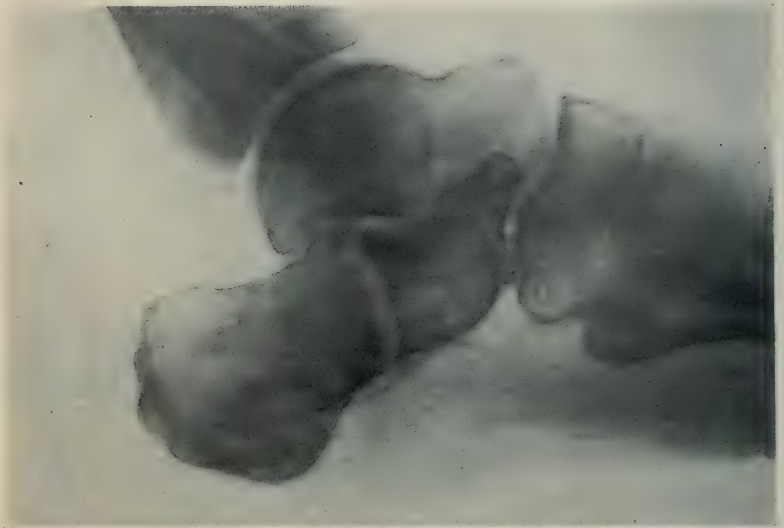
Fracture of the os calcis. This patient, a man, fell 15 feet on to frozen ground, striking upon both feet, in February, 1899. Right heel showed abnormal mobility and crepitus over the os calcis. X-ray shows comminuted fracture with large heel fragment. Treated with pillow splint; later, plaster of Paris bandage.
